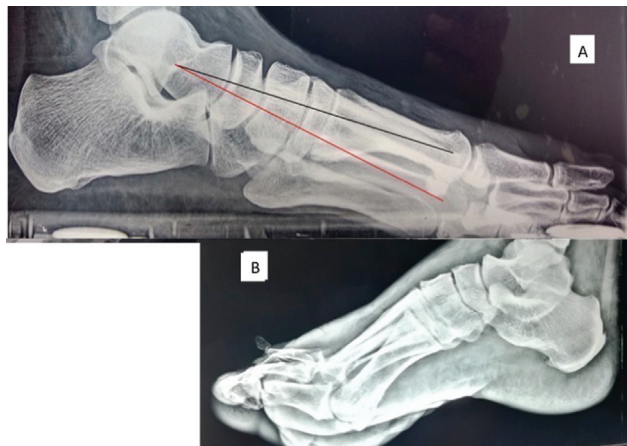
(A) Superimposed straight lateral weight bearing (red line) and nonweight bearing (black line) X-ray foot showing plantar luxation of metatarsal head (a mobile deformity). (B) Computed tomography para sagittal section showing the plantar luxation of the head of the first metatarsal bone. X-ray showing the plantar subluxation of the head of the first metatarsal bone on weight bearing.
